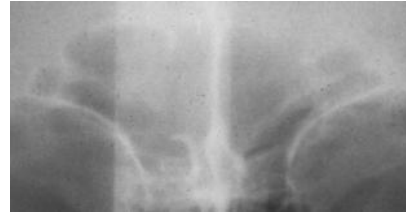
Frontal sinus image obtained from a radiograph.
